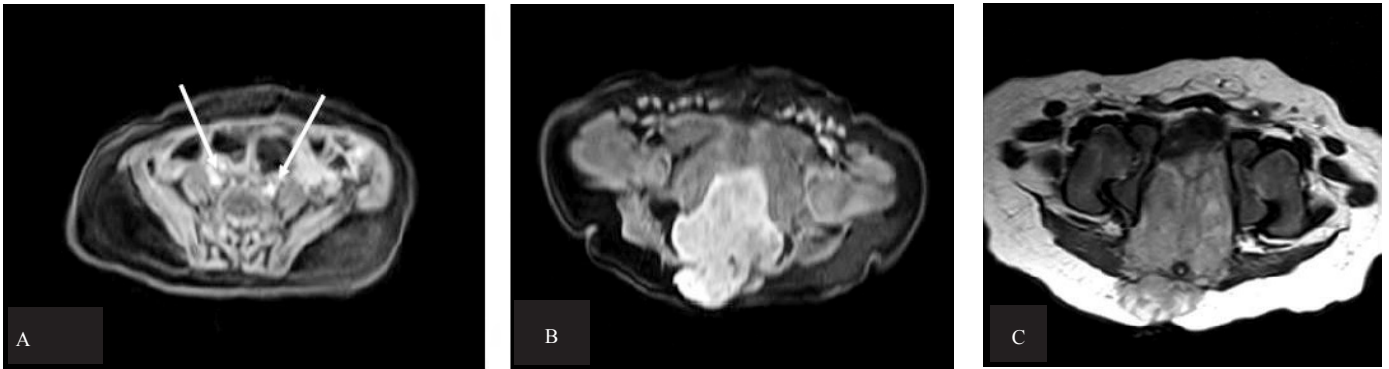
A: The T1-weighted MR images show that the tumor does not exist at aortic bifurcation level (A) (White long arrows=right and left iliac arteries), starting from lower levels extending down to the coccyx (B) and having heterogeneous signal intensity. C: A 5x6x6 cm soft tissue mass, starting from the presacral compartment at the sacrococcygeal region, surrounding the coccyx, spreading from the pelvic cavity anteriorly and reaching the subcutaneous tissue anteriorly, displacing the urinary bladder and rectum on T2 weighted series.
